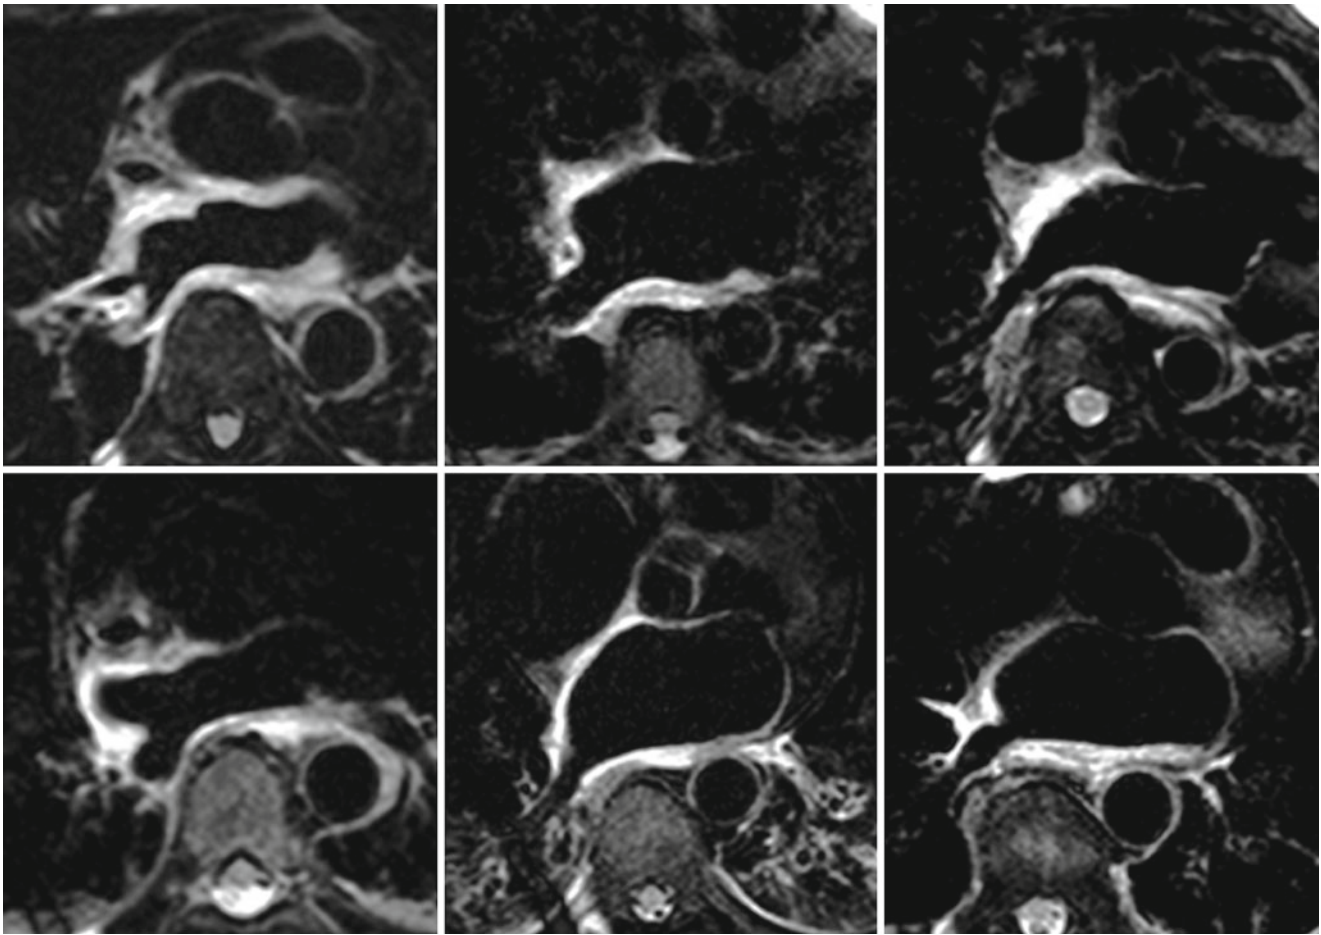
Post-ablation edema extends beyond ablated regions.* Cardiac MRI from six patients post-AF ablation demonstrates edema (bright T2w signal) extending not only in regions where RF energy was
